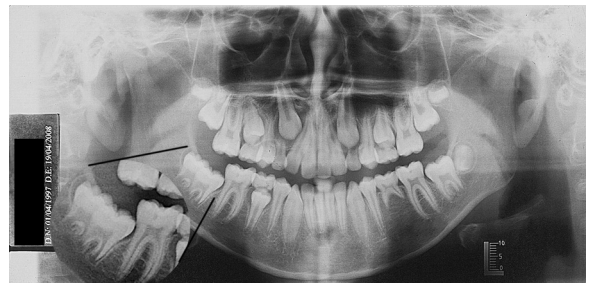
Panoramic Radiography (PR) for initial orthodontic treatment, showed second premolar agenesis (mandibular left region—35) and a second molar (mandibular right) apparently overlaid on the third molar, see that this tooth has more advanced root development than their congeners.
